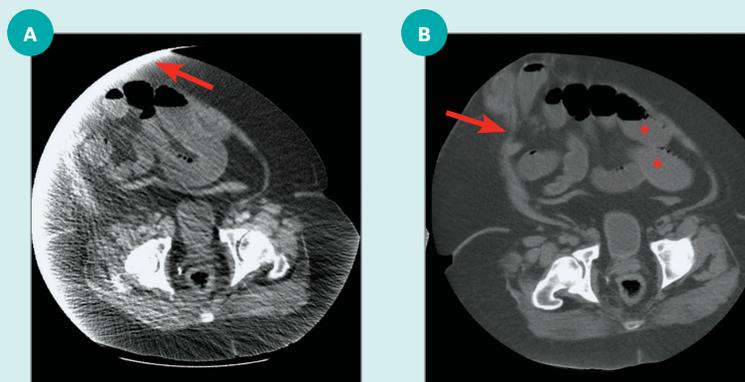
A 51-year-old male weighing 361 lbs (164 kg) presented with acute abdominal pain and underwent (A) abdominal CT on a 16-slice scanner with 120 kVp. However, the bore size restrictions limited the field-of-view causing artifacts (arrow) that obscured peripheral portions of the image. (B) Repeat CT on Revolution CT performed at 140 kVp had better image quality and depicted the cause of abdominal pain, incarcerated anterior abdominal wall hernia (arrow) causing small bowel obstruction (asterisks) that was otherwise obscured by the artifacts on the 16-slice CT scanner.
